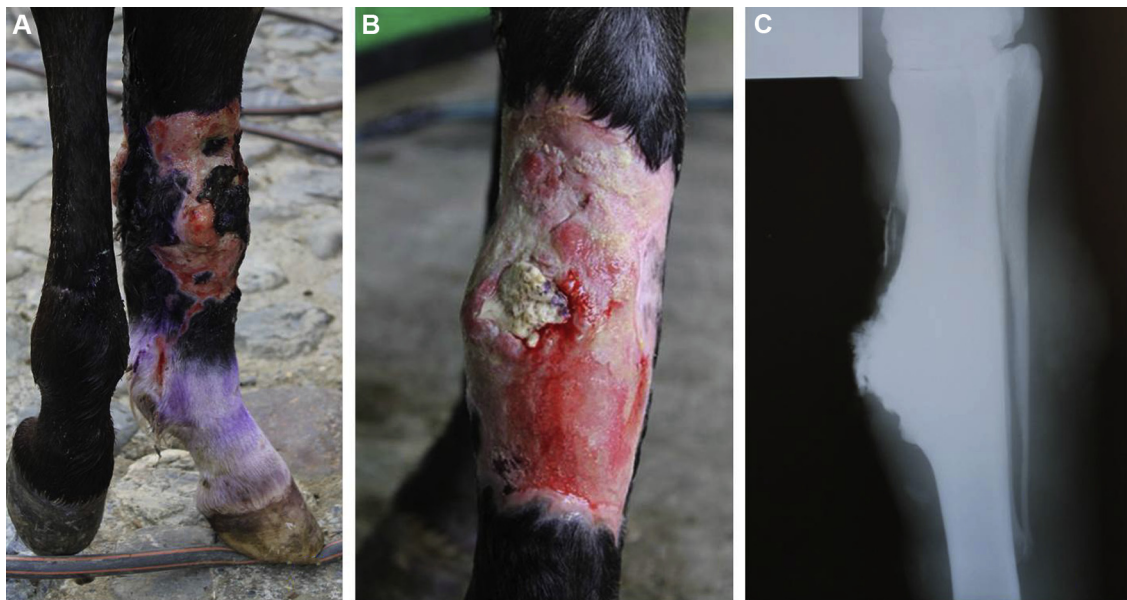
(A) The wound was severely contaminated and presented a bad smell. (B) Swollen zone with exaggerated granulation tissue and an osseous sequestrum exposition. (C) Lateral radiograph image demonstrating proliferative exostosis and fragments of demineralized bone.
